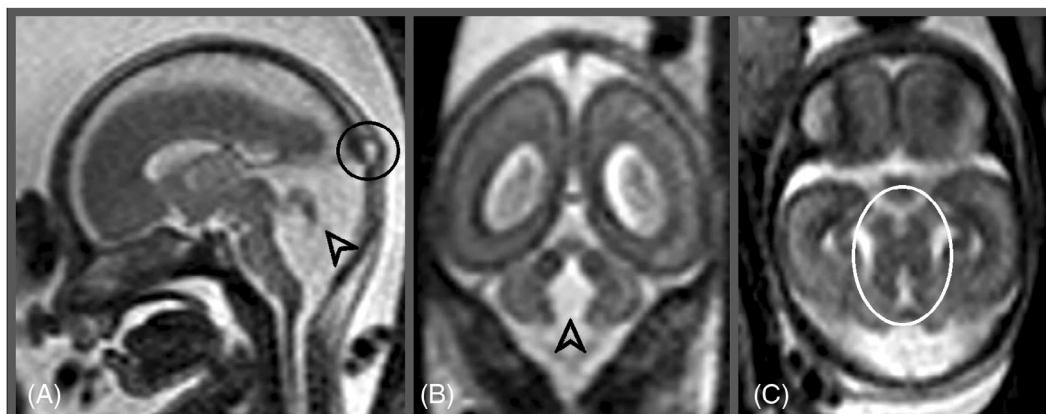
Molar tooth sign at 21 GW. (A) Sagittal T2-weighted image shows dysmorphic, hypoplastic vermis (arrowhead) and concurrent occipital meningocele (black circle). (B) Coronal T2-weighted image shows wide communication between the fourth ventricle and cisterna magna (arrowhead). (C) Axial T2-weighted image shows typical “molar tooth” appearance (white circle)
